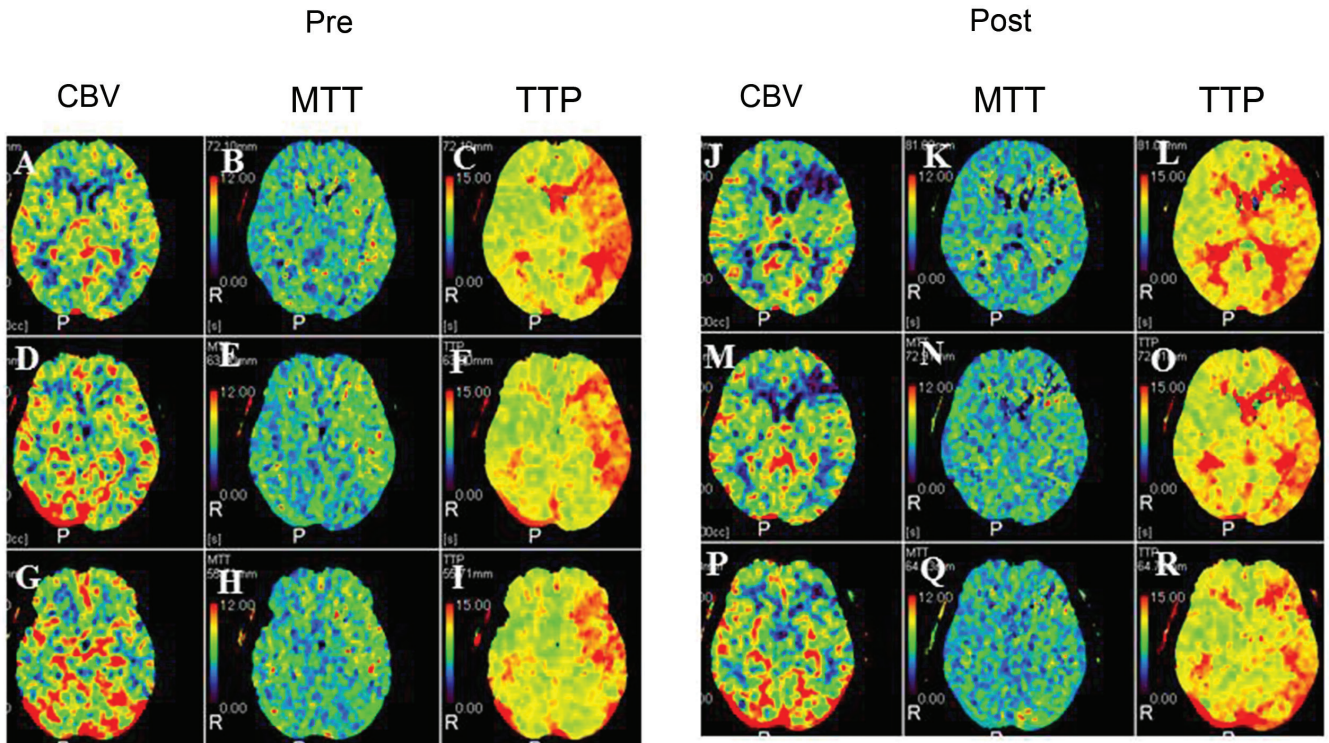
A computed tomography (CT) perfusion study after removal of the thyroid tumor with common carotid occlusion showed an increase of cerebral vascular volume (CBV), and a prolongation of the mean transit time (MTT) and time to peak (TTP) in the extent frontal lobe and -left side (A–I). After reverse single bypass, postoperative CT perfusion showed a decrease of CBV, a normalization of MTT and TTP in the extent frontal lobe and -left side (J–R).
